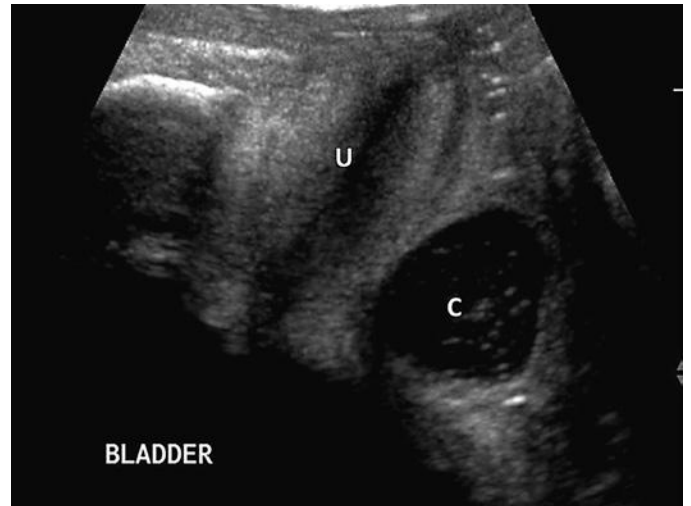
Gartner duct cyst. A transperineal sonogram shows a minimally complicated Gartner duct cyst (C) within the connective tissue adjacent to the vagina. U, urethra.
